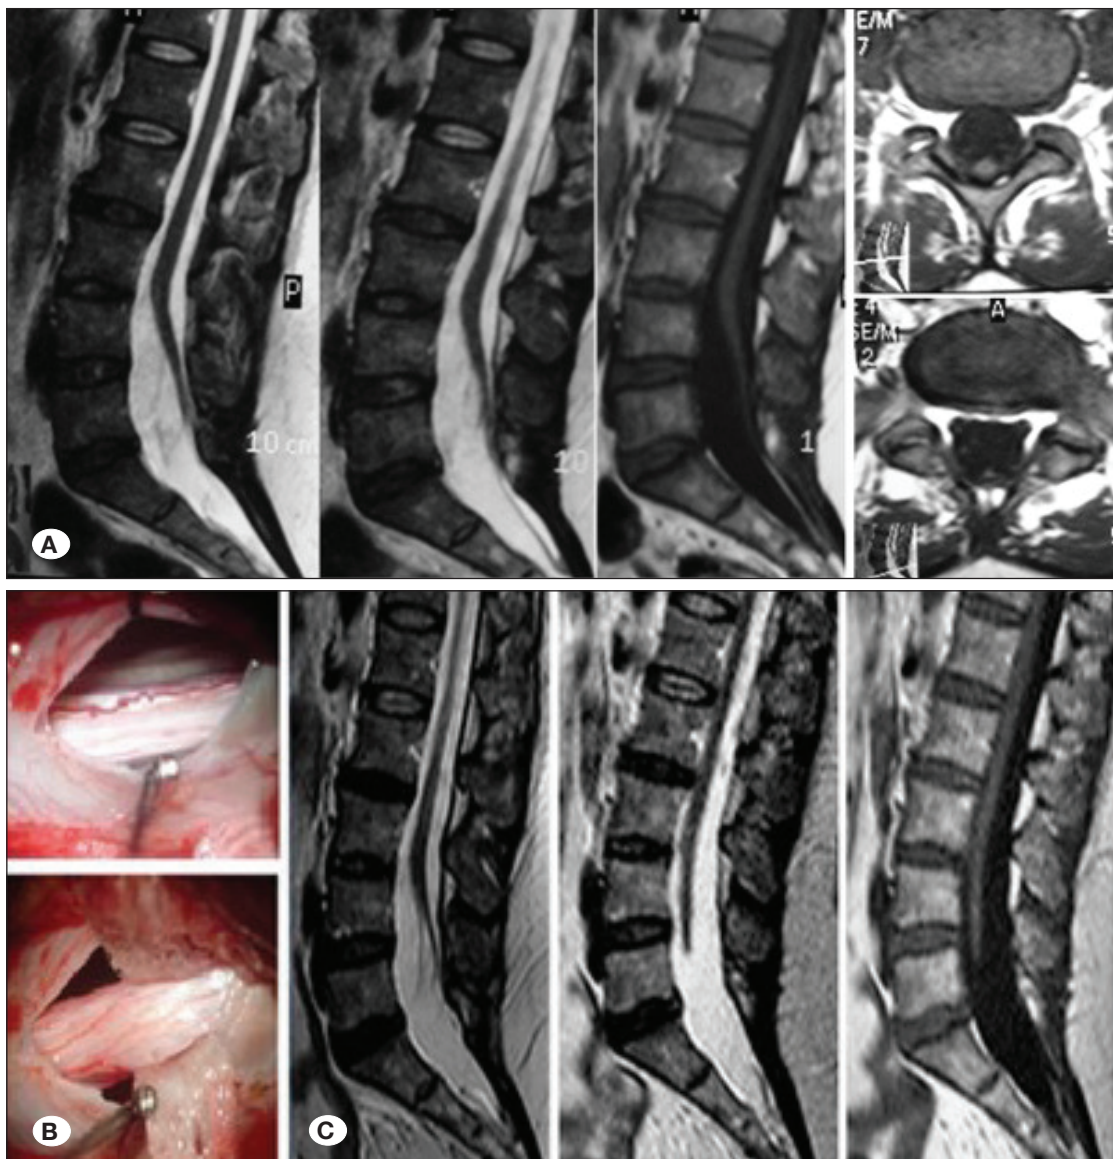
A) A 35 year-old female patient with bilateral leg pain, numbness, and frequent urination for 3 years. T2W and T1W sagittal, T1W axial MRI images show the TCS. The conus appears to end in the L4-5 levels. B) Operative view of filum terminale. C) Postoperative 10 years control. There are no symptoms. The control sagittal MRI images (left; supine, middle, and right; prone position) showed that there is no tethering.
